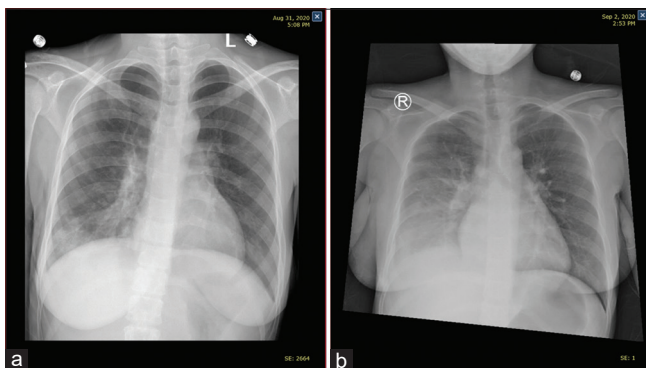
Chest Xray showed radiological progression of case 2
